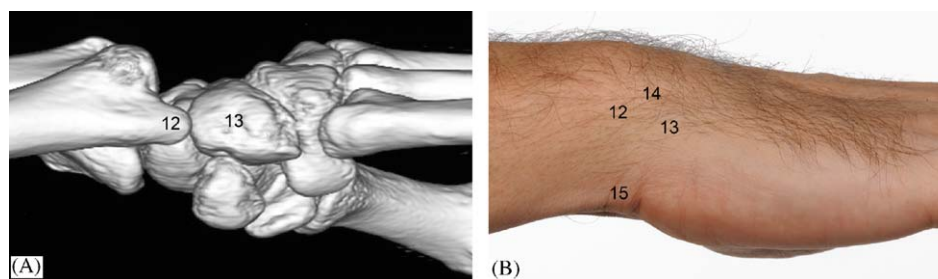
Medial (ulnar view) of the carpus and wrist as 3D CT reconstruction (A) and clinical photograph (B). Landmarks in both figures are—(12) ulnar styloid, (13) triquetrum, (14) extensor carpi ulnaris, (15) flexor carpi ulnaris.
